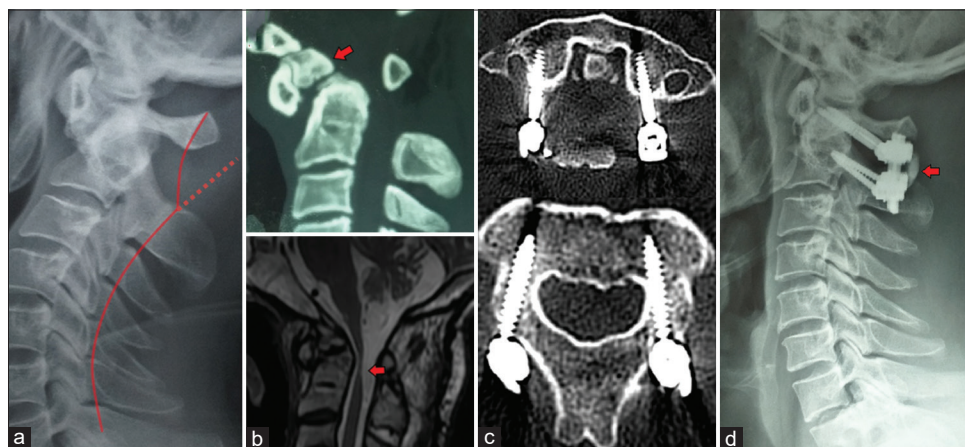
Imaging from case 5; male of 47 years old with Os odontoideum. (a) Preoperative lateral X-rays showing atlantoaxial dislocation cleared by the band of spinolaminar virtual line at the level of C1 (continuous line shows the actual line whereas the discontinuous line shows its normal position). (b) Sagittal computed tomography and magnetic resonance imaging; the arrow in the upper image shows Os odontoideum on computed tomography and the arrow on the lower image shows on magnetic resonance imaging the hypotrophy caused by chronic aggression and compression of the spinal cord. (c) Postoperative axial computed tomography; in the upper image passing through the atlas and in the lower image passing through axis. (d) Postoperative lateral X-rays showing the construct placement, the arrow is pointing to the graft placement
